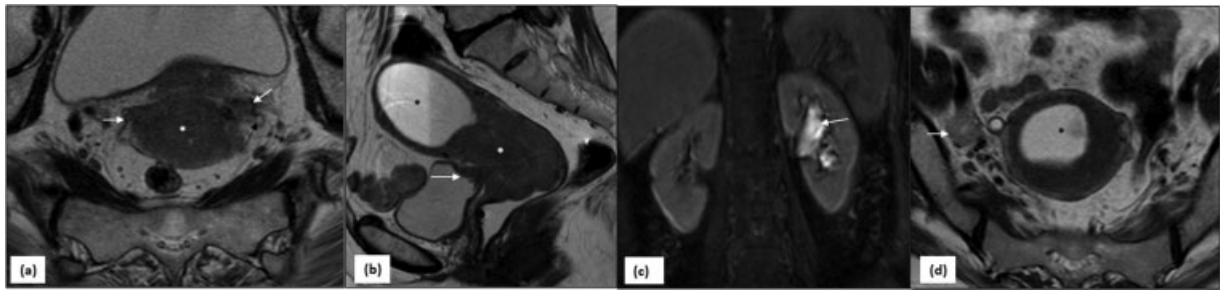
MRI in stage IVA of carcinoma cervix—(a) Axial and (b) sagittal T2W MRI images show infiltrative mass (*asterisk*) replacing the cervix with bilateral parametrial and posterior urinary bladder wall infiltration (*arrows*). Obstruction of cervical canal causes upstream hydrometra (*black asterisk*) with fluid debris within. (c) Encasement of left ureter (*black arrow* in a) has caused left hydronephrosis (*arrow* in c). (d) Axial section through the level of uterus in a different patient shows hydrometra with enlarged heterogeneous lymph node along the iliac vessels (*arrow*).
